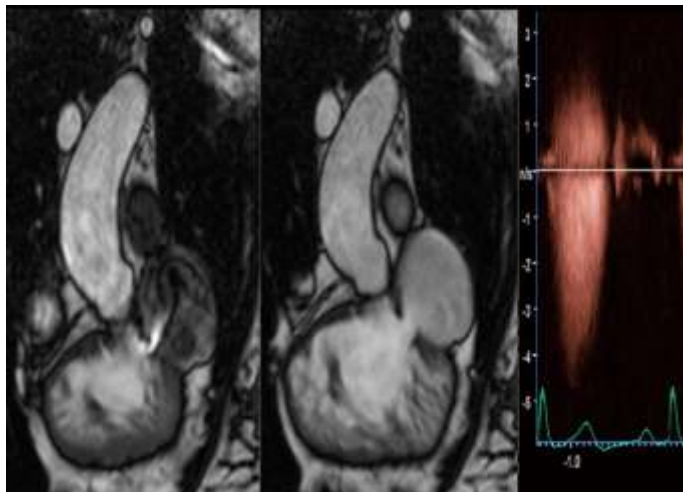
CMR cine images depicting a patient with PS in systole (left) and diastole (center). The doppler curve (right), with a maximum velocity close to 5 m/s, resembles an aortic stenosis curve, and corresponds to severe PS. CMR, cardiac magnetic resonance; PS, pulmonary stenosis. (16).
